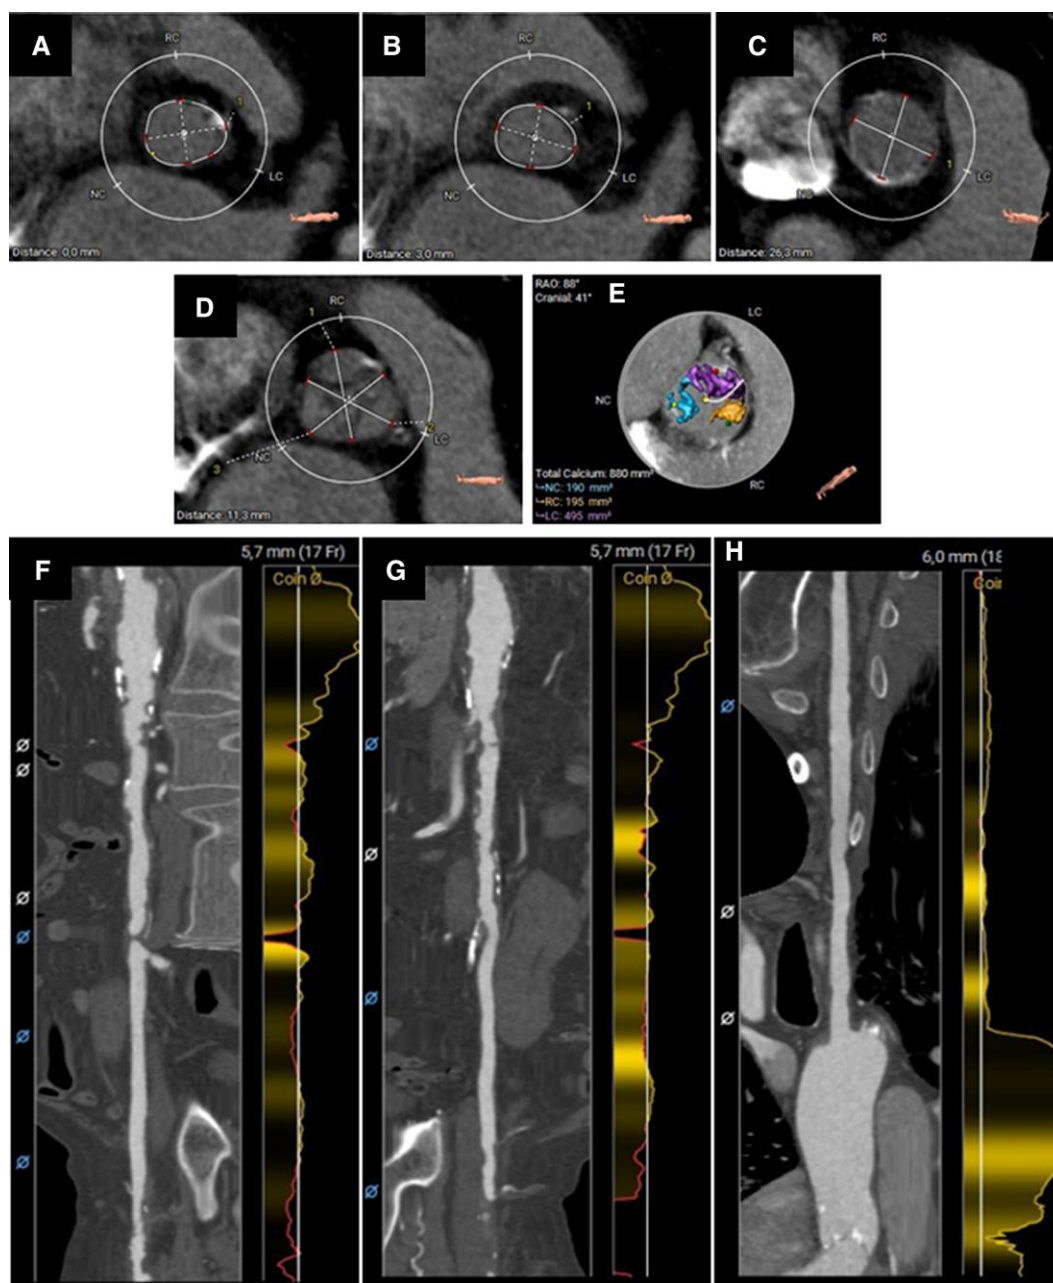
Computed tomography analysis. Panels are arranged from left to right and from top to bottom: (A) Aortic annulus sizing: area 376 mm², perimeter 70 mm; (B) Left ventricular outflow tract sizing: area 365 mm², perimeter 69 mm; (C) Sinotubular junction with mean diameter of 26.1 mm; (D) Aortic sinus measurements: right sinus 27.4 mm, left sinus 28.7 mm, non-coronary sinus 28.5 mm; (E) calcium distribution on aortic leaflets and annulus, (F) Right ilio-femoral axis with right common iliac artery occlusion; (G) Left ilio-femoral axis with occlusion of left common femoral artery just above the bifurcation; (H) Left subclavian and axillary axis.
